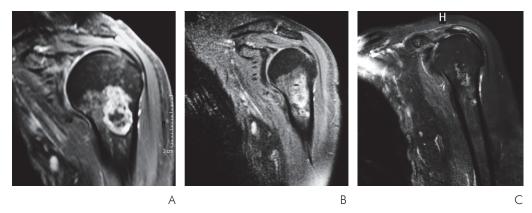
A series of T2-weighted Gd-MRI scans of a 62-year-old female patient with a grade I chondrosarcoma.
